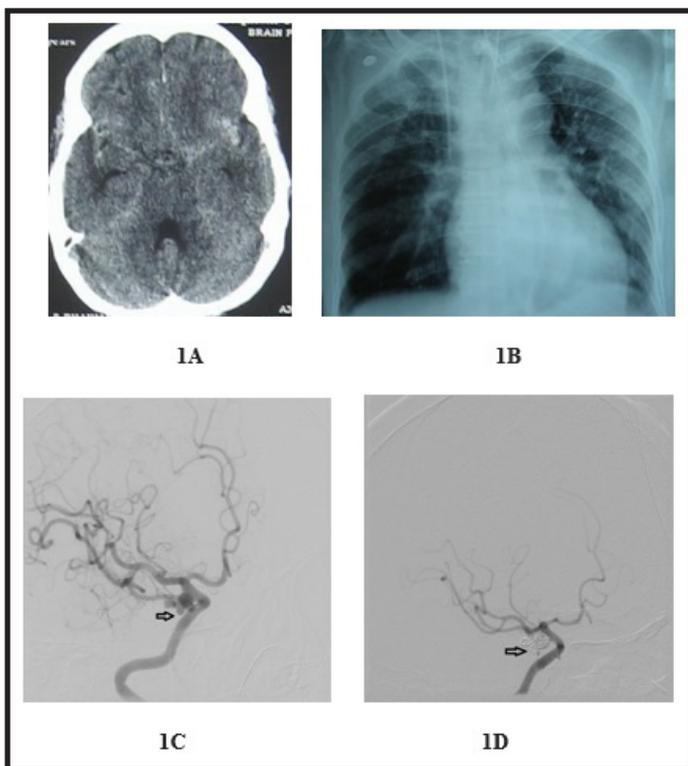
1A. Showed diffuse SAH with extension into bilateral sylvian fissures. 1B. Showed radiograph of chest depicting pulmonary edema in predominantly upper zones, DSA. 1C. Showed multilobed aneurysm (Arrow) of communicating segment of right ICA DSA. 1D. Showed complete exclusion of the aneurysm from circulation by endovascular coiling (Arrow showed coil mass). Please note there is no vasospasm seen.
